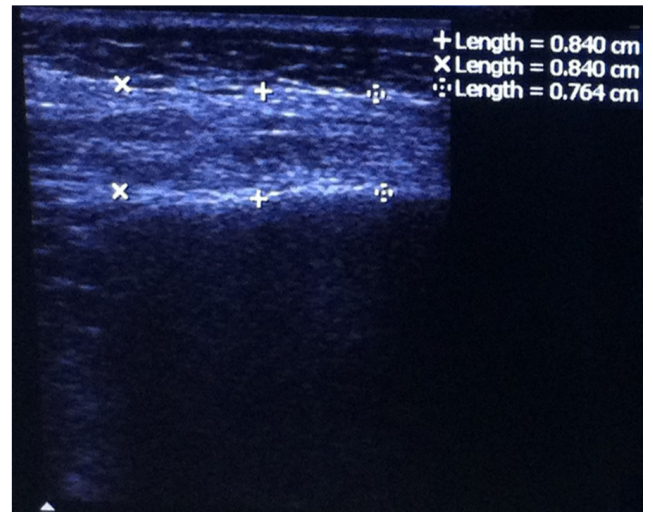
Ultrasonographic image of the masseter muscle in a healthy person – contracted state
